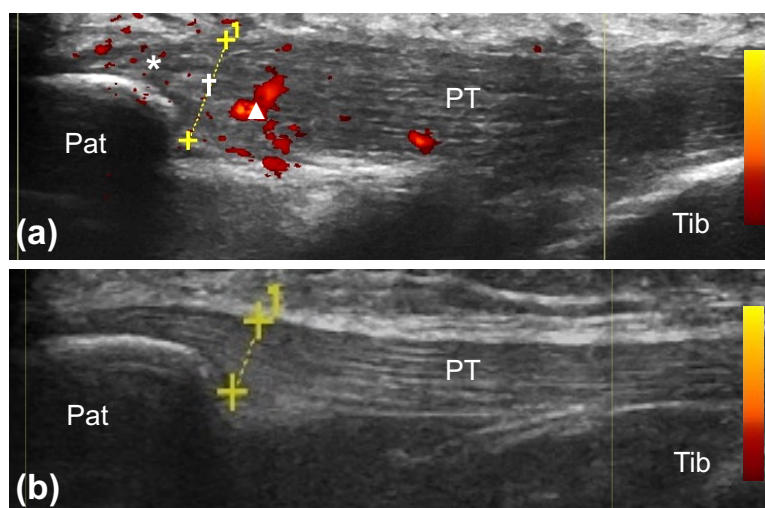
Reduction in enthesal thickness (†, grade 2 to 0), hypoechogenicity (★, grade 1 to 0) and power doppler signal (▲, grade 3 to 0) within the left proximal patellar tendon enthesis between week 0 (a) and week 52 of ustekinumab therapy (b). PT: Patellar tendon; Pat: Patella; Tib: Tibia.
